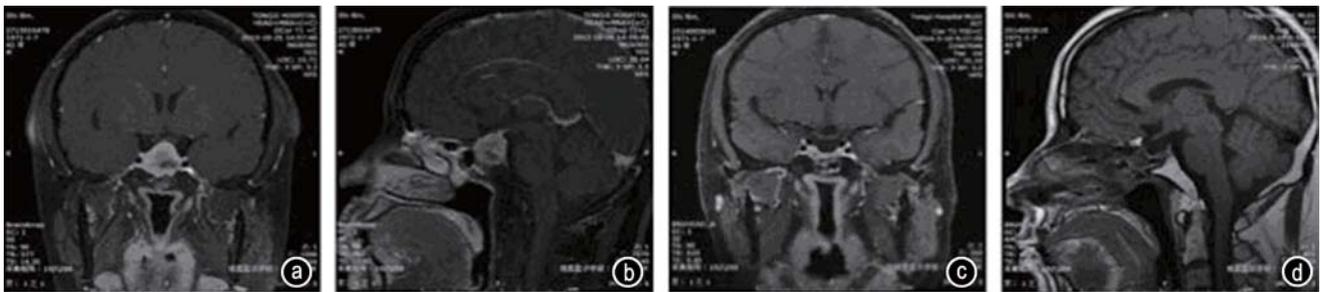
Representative preoperative (a and b) and postoperative (c and d) MRI of a male prolactinoma patient with DA pretreatment
